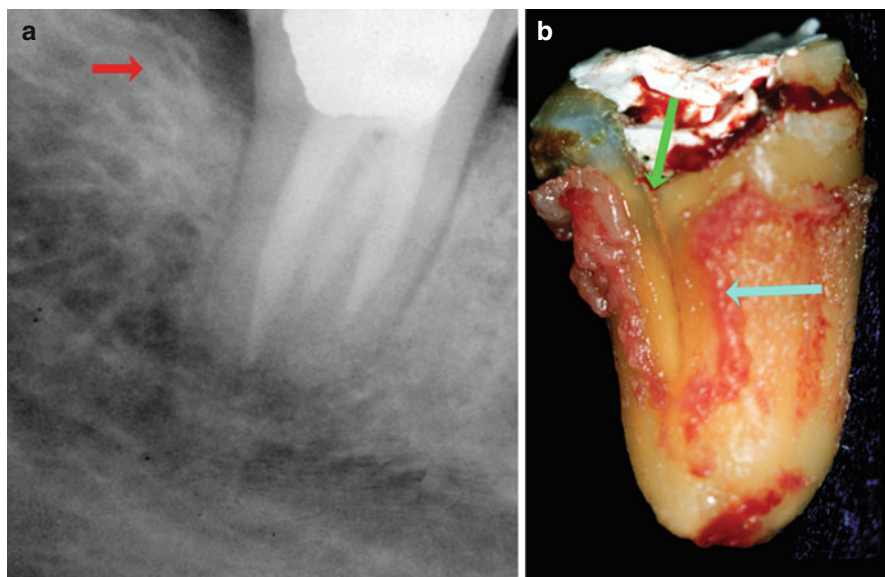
(a) Periradicular radiograph of a mandibular second molar tooth showing an angular bony defect adjacent the distal root of the tooth; (*red arrow*). (b) The same tooth extracted showing the fracture line on the distal root (*green arrow*) and the position of the periodontal ligament adjacent to the fracture line (*blue arrow*)
